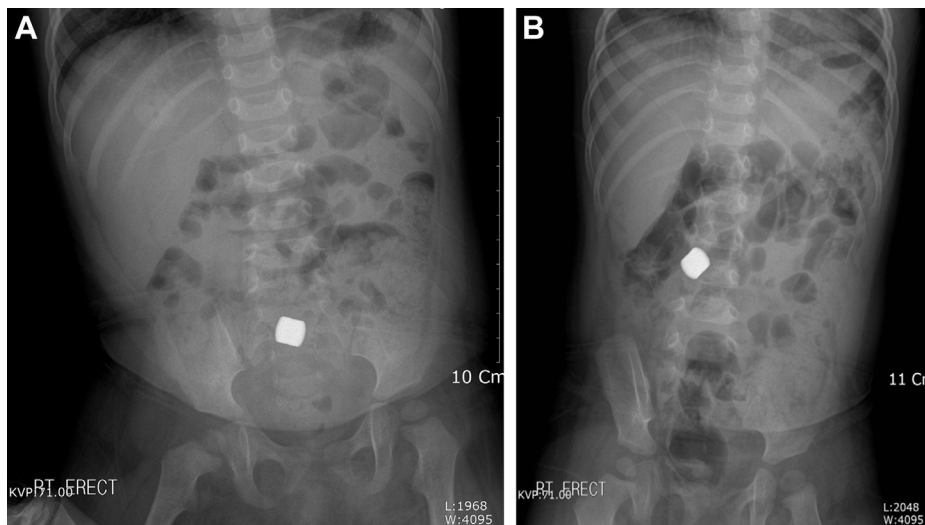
(A, B) Abdominal X-ray shows a metallic foreign body moving up and down in serial follow-up. It is uncertain whether the foreign body is a single magnet or attached multiple magnets.
